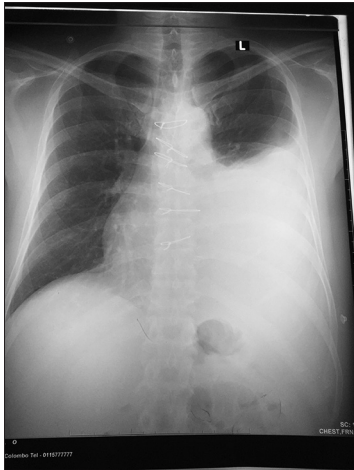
X-ray shows massive left pleural effusion day 5
